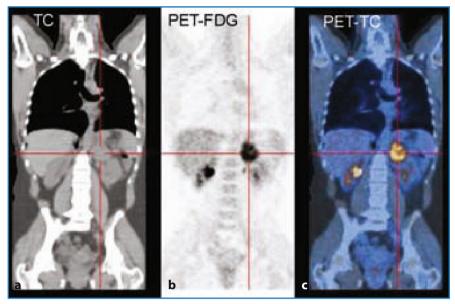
FDG-PET (b) and CT-PET (c) of adrenocortical carcinoma. PET of a small left adrenal incidentaloma is shown. It was iso-dense at CT (a), which is a suspicious criterion of malignancy, so FDG-PET and PET-CT were necessary, even if the mass did not share a dimensional aspect typical of adrenocortical carcinoma (dimension, ≈ 3.9 cm). The final diagnosis was a small adrenocortical carcinoma at a very early stage (T1 according to the WHO classification)
